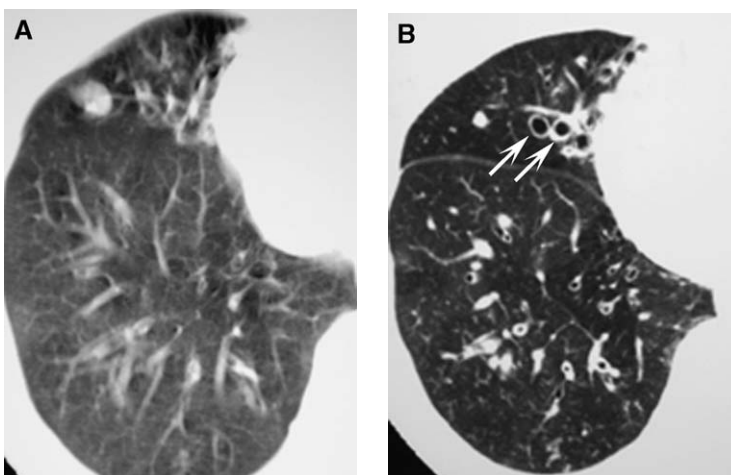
Pitfalls in the HRCT assessment of bronchiectasis: wide collimation and respiratory motion. (A) Coned axial CT image obtained with 7-mm collimation and degraded by respiratory motion fails to demonstrate bronchiectasis clearly. (B) Coned axial HRCT image clearly shows bronchiectasis in the right middle lobe (arrows) and the right lower lobe.
